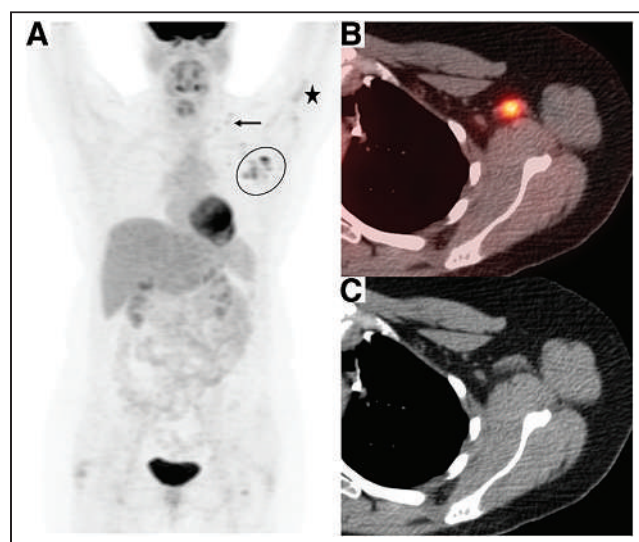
(A) Maximum-intensity-projection image demonstrating cluster of hypermetabolic left axillary lymph nodes (encircled), cluster of hypermetabolic supraclavicular lymph nodes (arrow), and faint intramuscular radiotracer uptake (star). (B and C) Representative left axillary lymph node that appears benign on axial CT image (C) but demonstrates increased uptake (SUV_{max} , 7.1) on axial ^{18}F -FDG PET/CT image (B).
